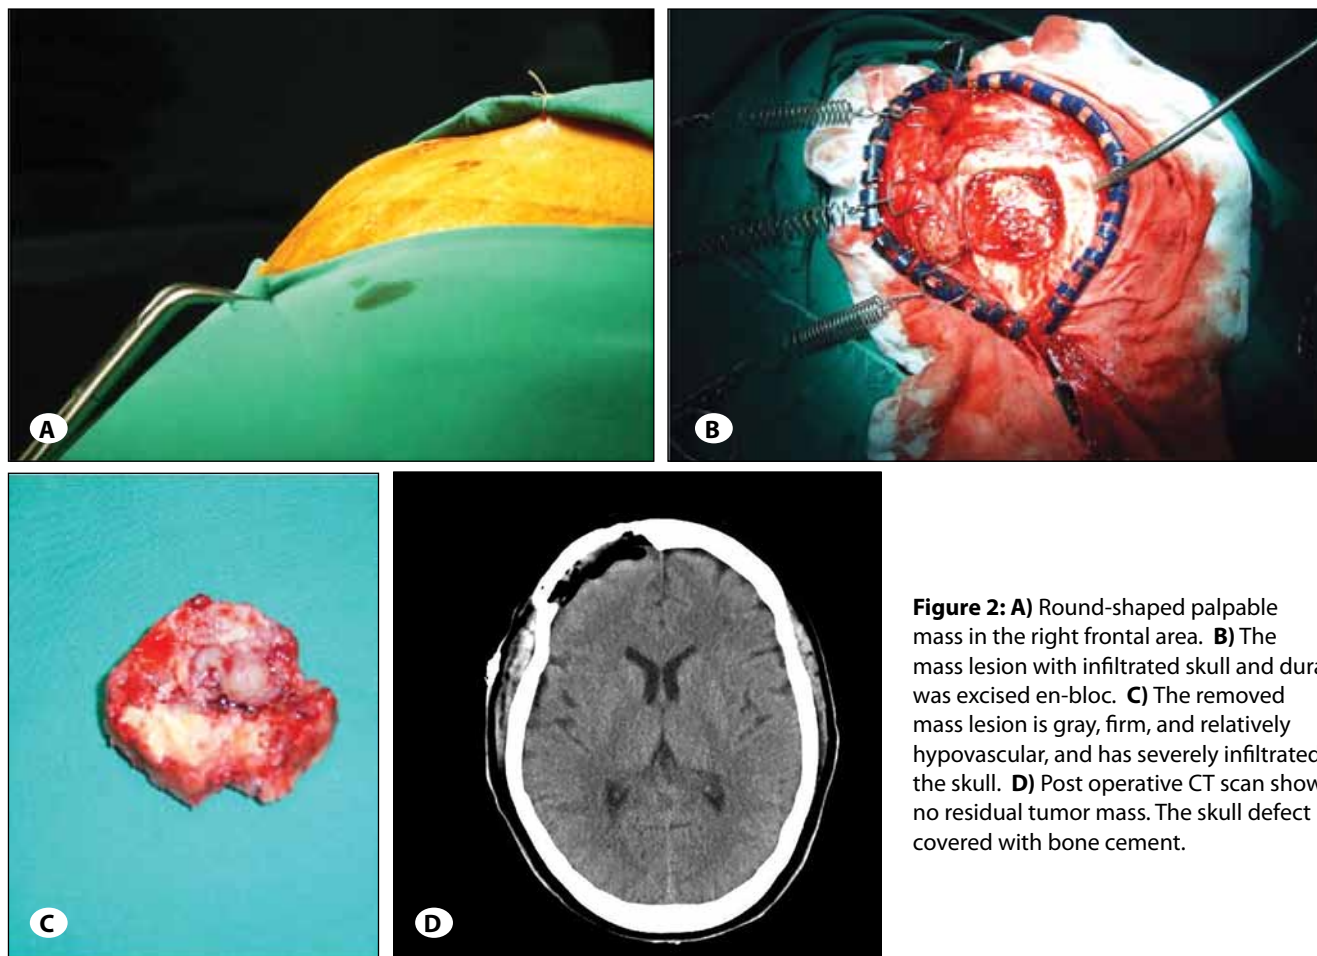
A) Round-shaped palpable mass in the right frontal area. B) The mass lesion with infiltrated skull and dura was excised en-bloc. C) The removed mass lesion is gray, firm, and relatively hypovascular, and has severely infiltrated the skull. D) Post operative CT scan shows no residual tumor mass. The skull defect is covered with bone cement.
